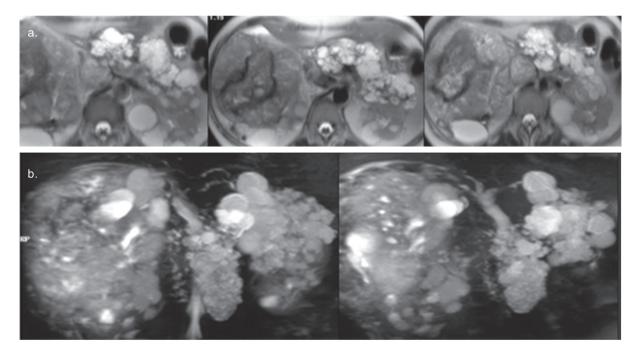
(a), (b) MRI. Multiple pancreatic cysts.
